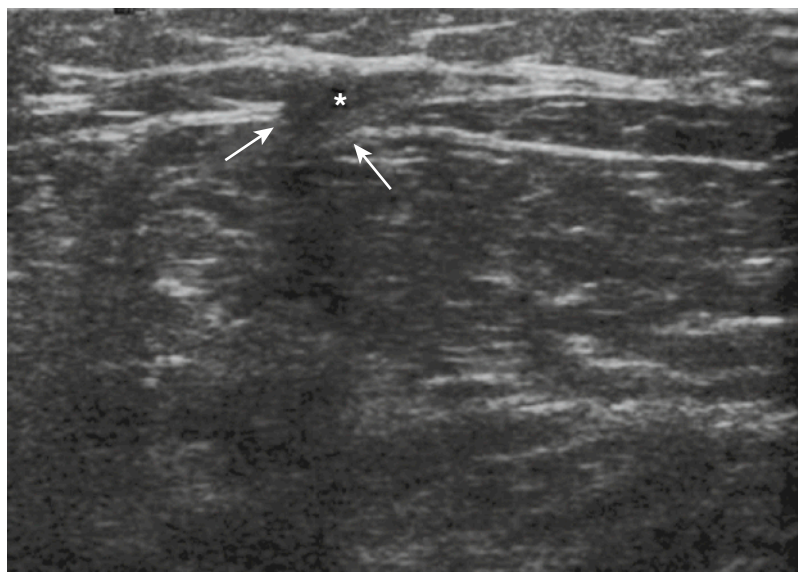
Longitudinal sonogram shows a fascial defect (arrows) of the tibialis anterior with a small muscle hernia (star).
